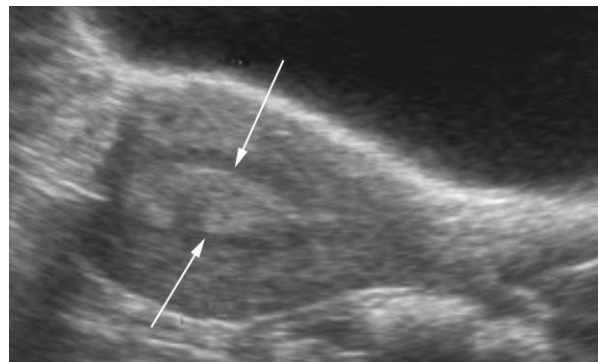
Endometrial cancer in a 60 year old woman with postmenopausal bleeding. This patient had a single episode of bright red blood followed by spotting. Endometrial biopsy resulted in a benign polyp and no malignancy. The ultrasound demonstrated a thick endometrial stripe, after which the patient had hysteroscopy and a D&C, with a diagnosis of endometrial cancer. This is an example of where the addition of an ultrasound study to endometrial biopsy resulted in improved patient management.
